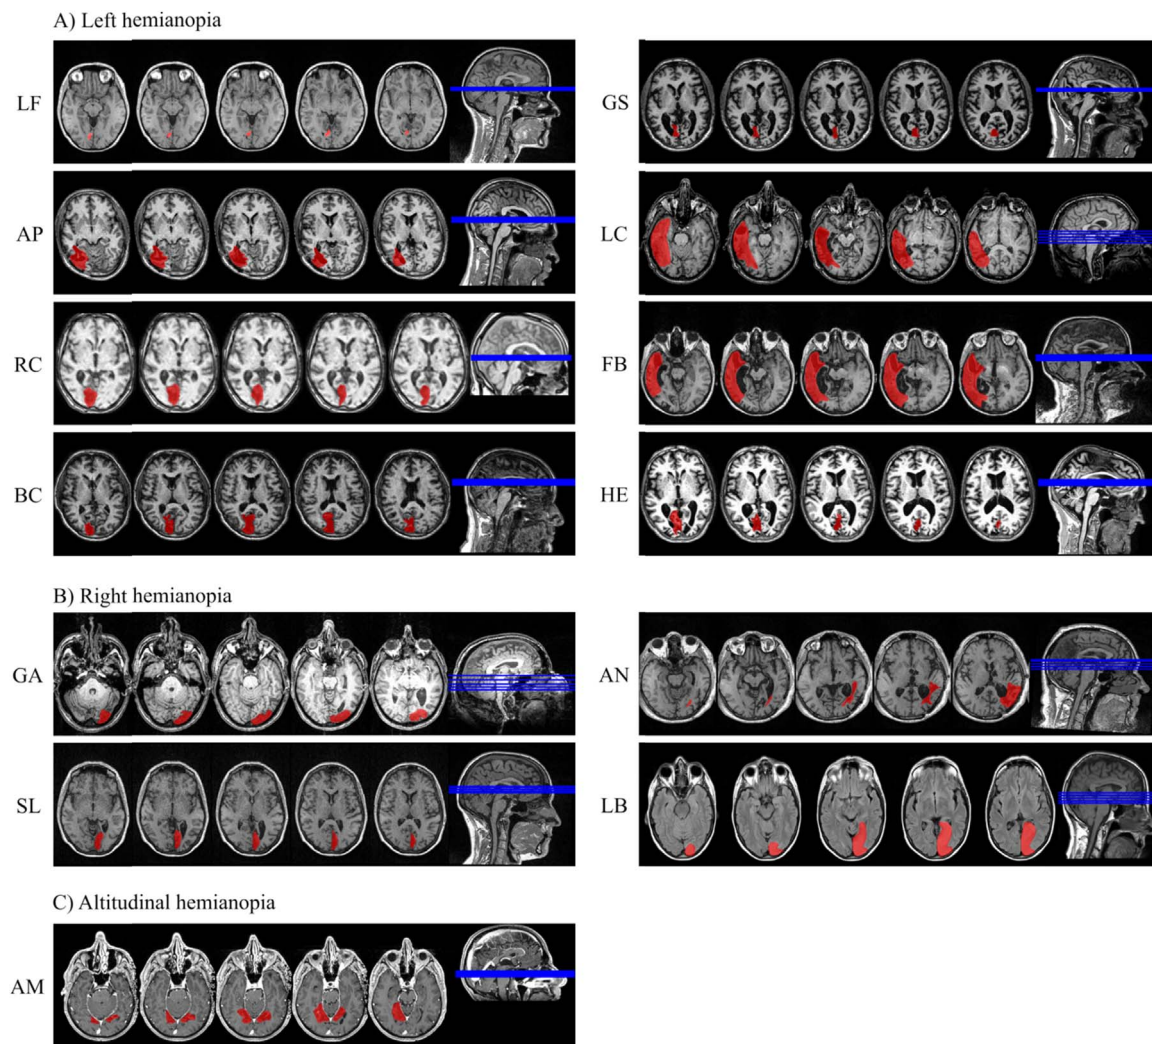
Patients' structural magnetic resonance images. Localization and extension of the lesions are drawn in red. A) right hemisphere lesion with resulting left hemianopia; B) left hemisphere lesion with resulting right hemianopia; and C) bilateral hemispheric lesion with resulting bilateral altitudinal hemianopia. Images are left-right oriented according to the radiological convention.
